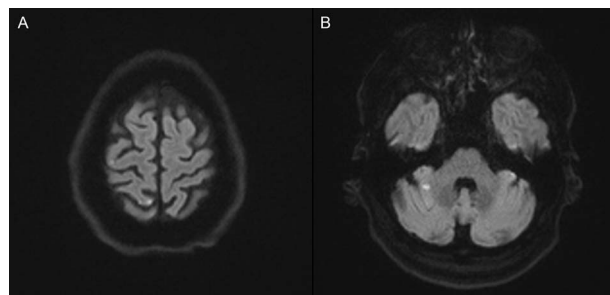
Brain magnetic resonance imaging (diffusion weight imaging) demonstrating multi-territory foci of restricted diffusion, including two in the right parietal vertex (A) and one in the right cerebellar hemisphere (B), consistent with embolic stroke.
